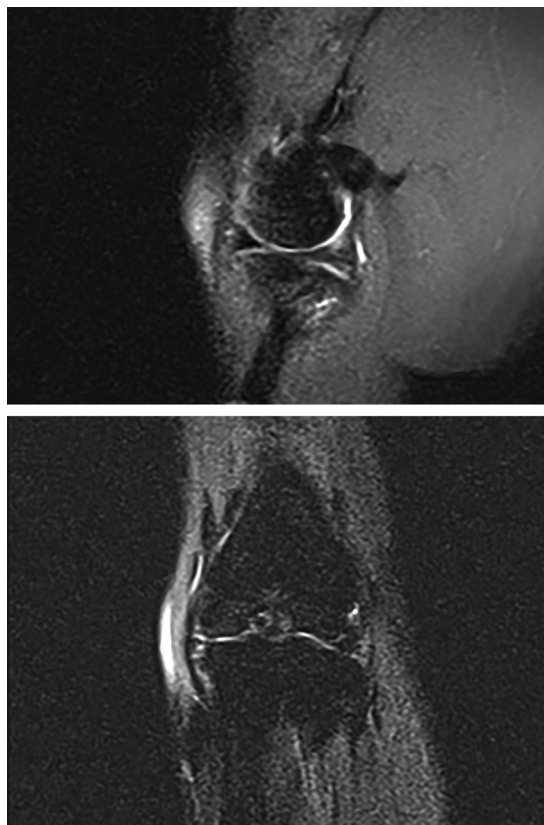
Magnetic resonance imaging of the left stifle joint: note a lateral contour loss and a diffuse hyperintense signal of the caudal horn of the medial meniscus.
